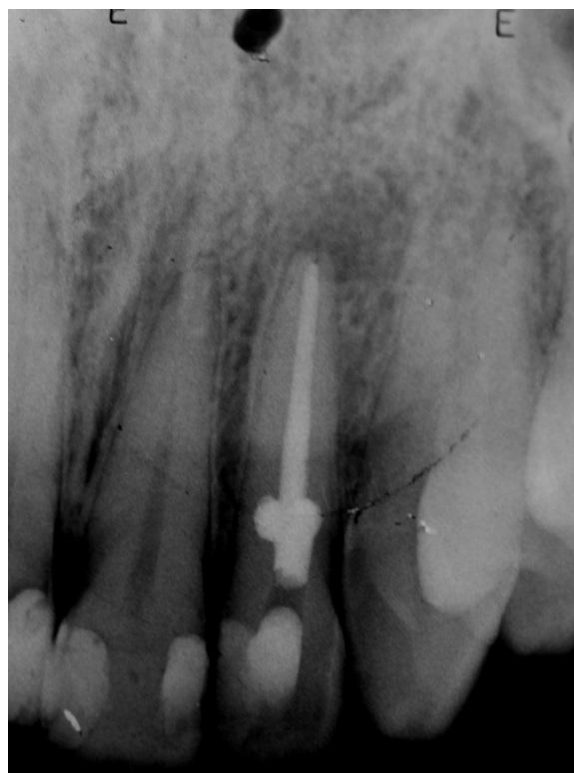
Final ortho radiograph
